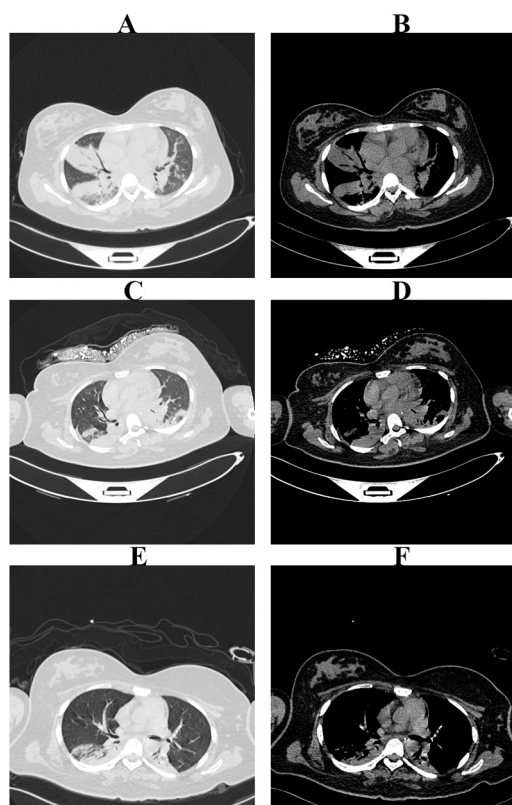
The chest CT imagines at different times: A, C&E indicated lung windows of lung CT at 1st, 14th, 28th day. B, D&F indicated mediastinum windows of lung CT at 1st, 14th, 28th day.
